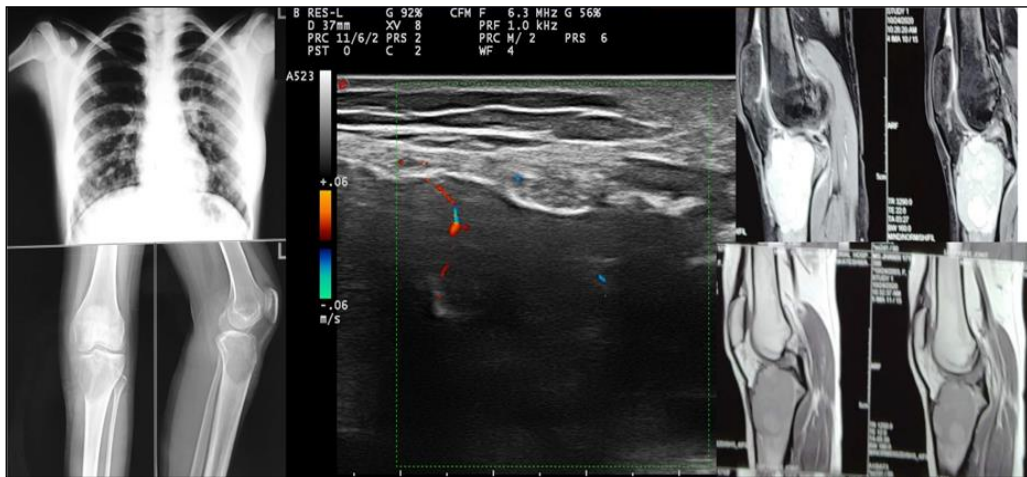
17/ F Grade III lesion in tibia with pulmonary metastases as shown in chest Radiograph. Lesion is isointense on T1W and hyper on T2W images and no extension to joint
